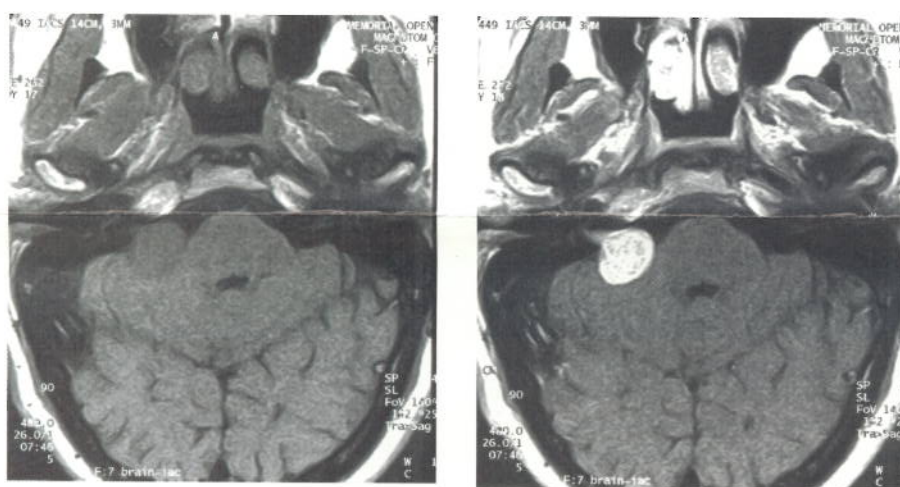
High field techniques benefit open MRI. RecFOV and Phase oversampling were used to obtain this aggressive 160 mm FOV, RecFOV 7/8, Phase Oversampling 25%, 3 mm slice, 7:45 min.
